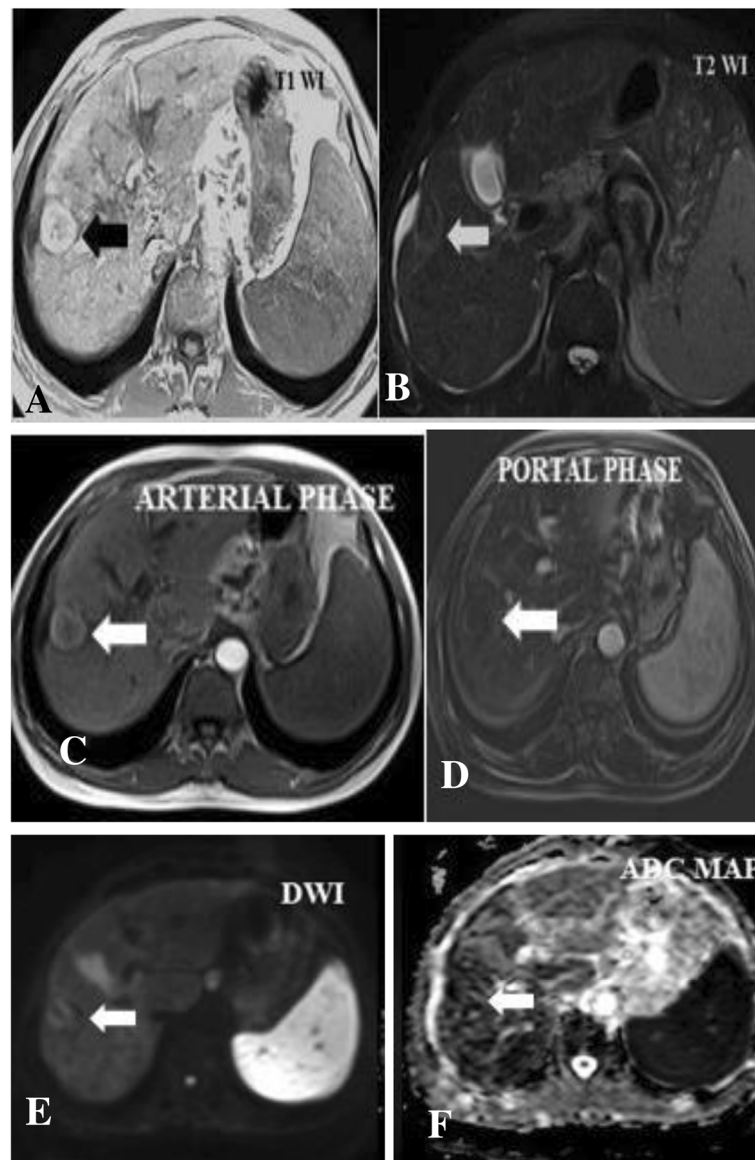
A 59-year-old female presented with right hypocondrial pain. a An axial unenhanced T1W image shows right lobe segment V focal lesion measuring 2 cm of isointense signal (arrow). b An axial T2W image showed a lesion of hyperintense signal (arrow). c An axial post-contrast arterial phase image shows homogeneous contrast enhancement (arrow). d, e An axial portal and the delayed post-contrast images show contrast washout (arrow). f DWI shows the lesion to be partially restricted (arrow). With ADC value of $0.9 \times 10^{-3} \text{ mm}^2/\text{s}$. Suggested MR diagnosis: HCC nodule. Biopsy results: HCC nodule
